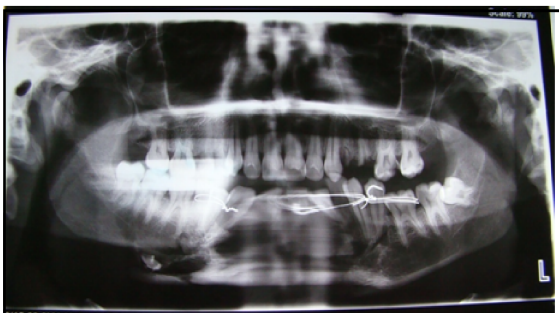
Post Operative Radiograph Showing Single Plate Showing Single Plate In Symphysis Fracture
